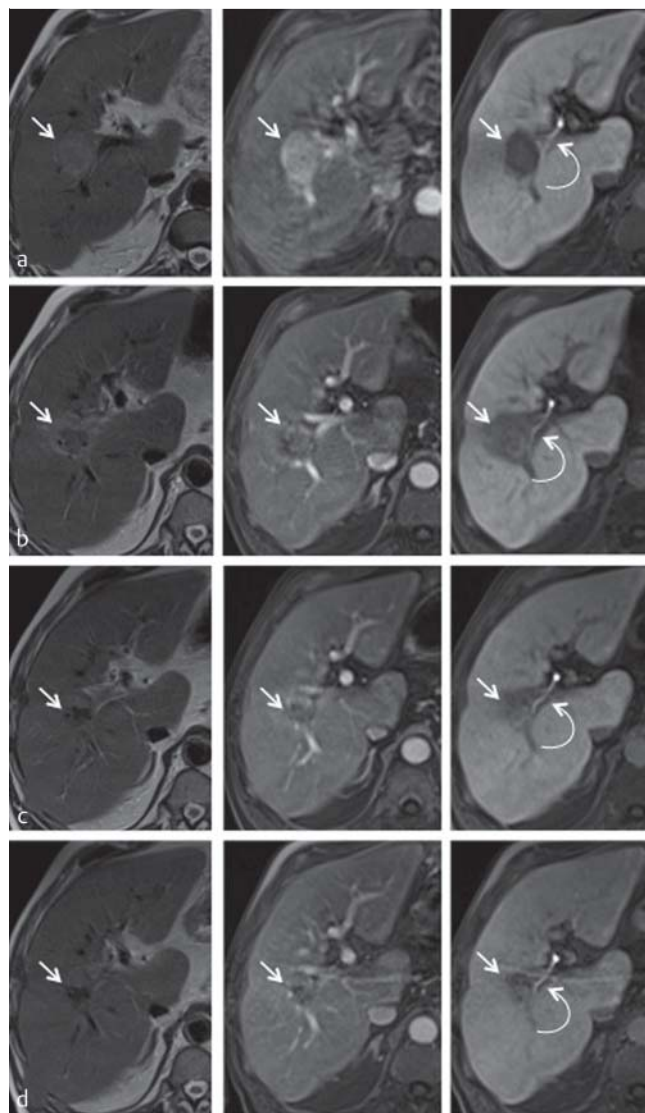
Patient with unresectable hepatocellular carcinoma (HCC). Pre-procedural pre- and post-contrast MRI scans a show a large HCC located close to the liver hilum. IRE was performed using five electrodes and follow-up MRI examinations at one b, three c and six d months demonstrate progressive shrinkage of the ablation zone (arrow) with good local tumor control. Furthermore, follow-up Gd-EOB-DTPA-enhanced MRI scans show the intact bile duct (bent arrow) located in the immediate vicinity of the ablation zone.
